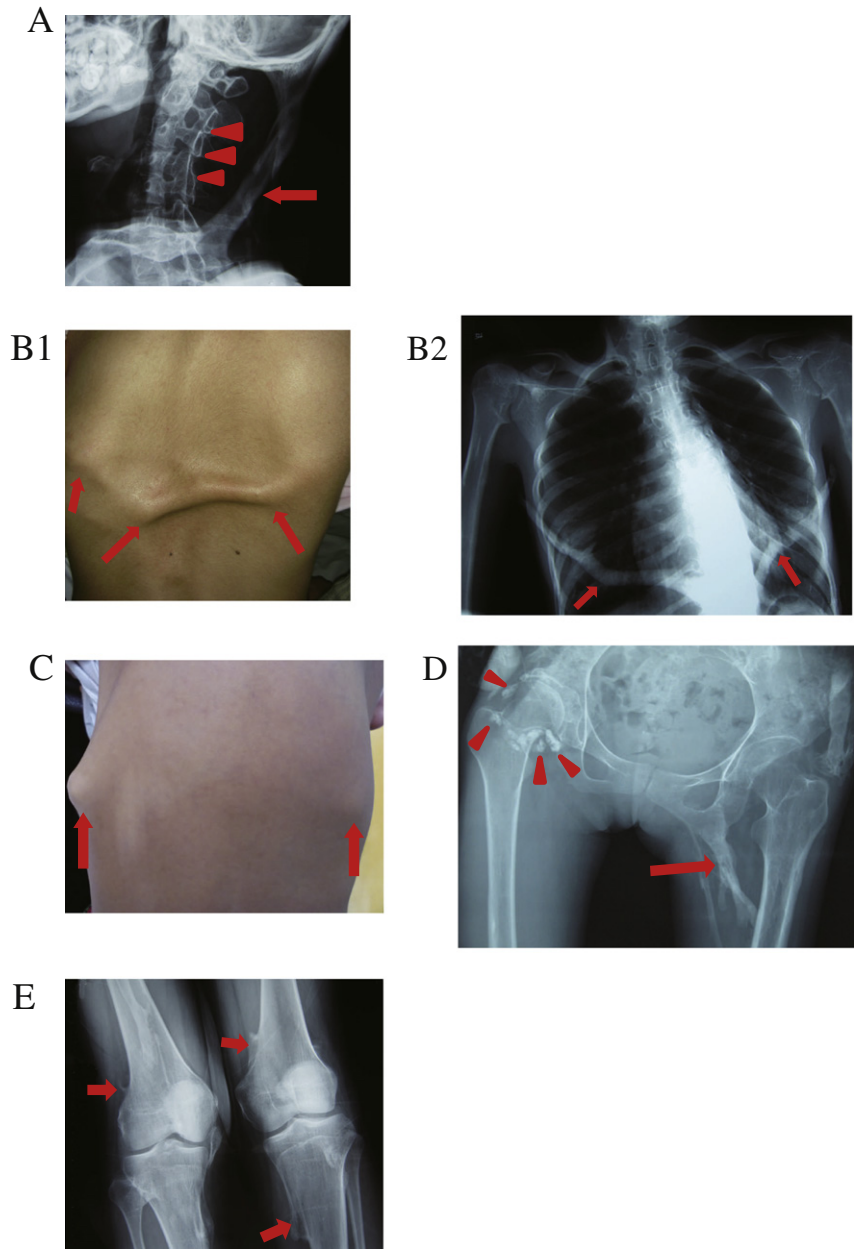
Characteristic and common-variable features of classic FOP [ACVR1/ALK2 (R206H)]. (A) Lateral radiograph of the cervical spine of a 22-year-old male FOP patient shows heterotopic bone in the nuchal ligament (arrow) and posterior orthotopic fusion of the facet joints of several cervical vertebrae (arrowheads). Photograph (B1) and anterior–posterior radiograph (B2) of the chest of a 16-year-old girl with classic FOP showing subcutaneous bands of heterotopic bone (arrows) in the back. (C) Photograph of the back of a 5-year-old girl with classic FOP showing two prominent subcutaneous flare-ups (arrows). (D) Anterior–posterior radiograph of the pelvis of a 29-year-old female with classic FOP showing mature heterotopic ossification bridging the left hip (arrow) and more proximally both the left and right pelvis, as well as intra-articular synovial osteochondromatosis of right hip (arrowheads). The patient also has characteristic femoral necks that are short and broad. (E) Anterior–posterior radiographs of the knees of a 22-year-old male with classic FOP showing a large sessile osteochondroma of the left proximal medial tibia and small pedunculated osteochondroma of the right distal femur (arrows). Additionally, there are prominent areas of heterotopic bone in both knees.
